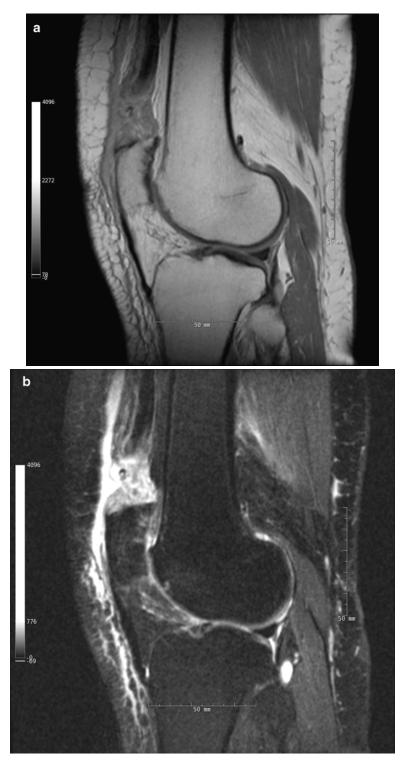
(a) Sagittal proton-density turbo spin-echo MRI of right quadriceps tendon rupture. (b) Sagittal proton-density turbo spin-echo fat-saturated MRI of right
